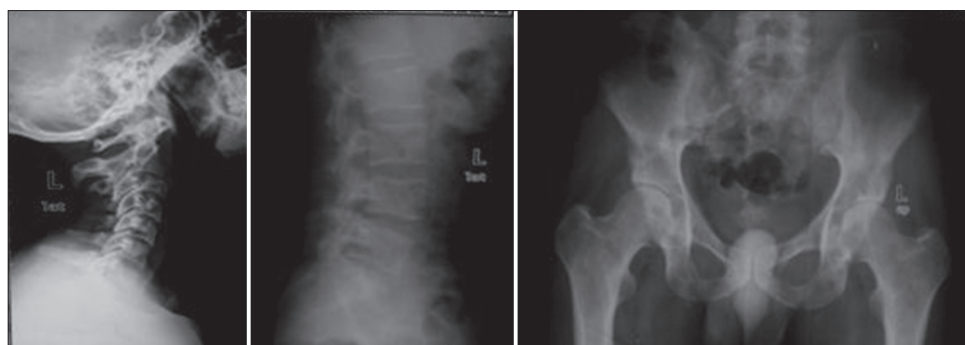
Radiograph showing multiple osteolytic lesions in the cervical, thoracic and lumbar spine and pelvis in case two
